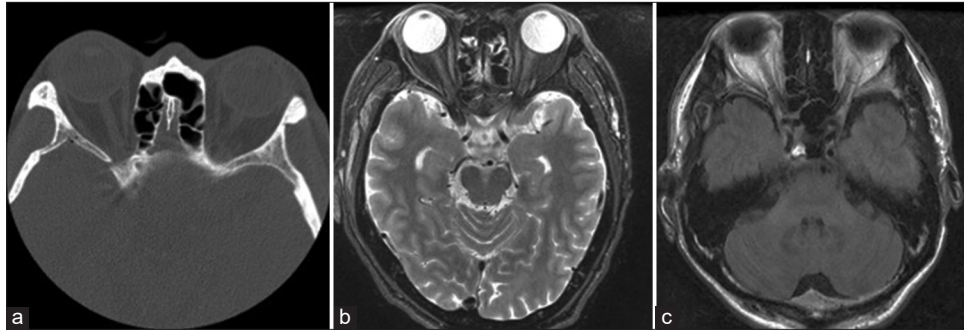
Computed tomography (CT) scan and magnetic resonance imaging (MRI) pre- and post-operatively. Thin-slice CT showing no optic canal fracture (a); MRI showing no intracranial traumatic lesions (b and c).
